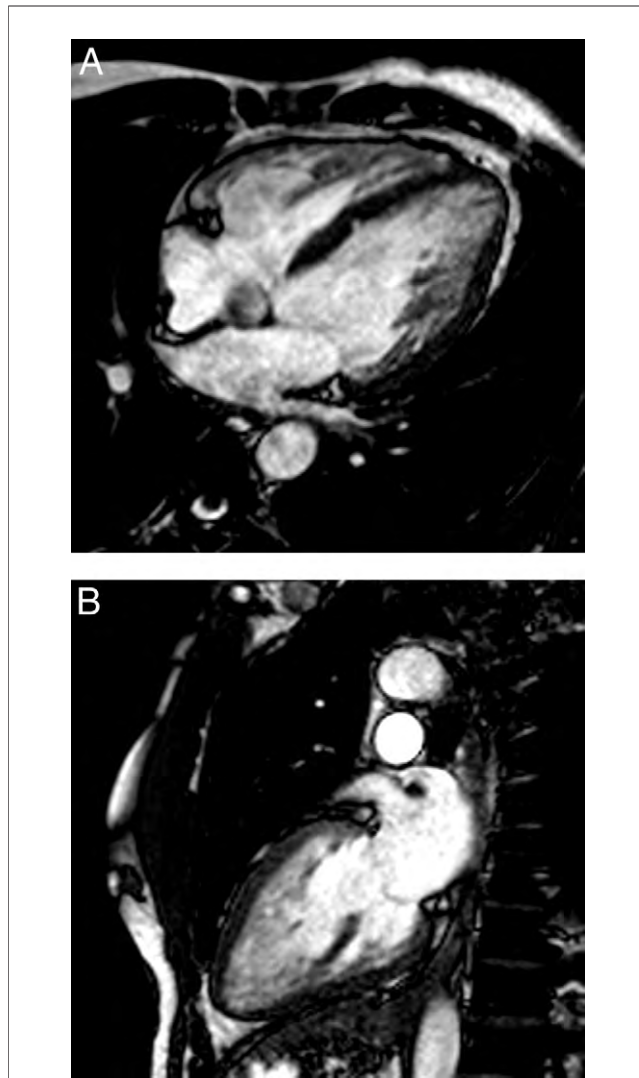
Cardiac Magnetic Resonance Imaging Demonstrating Morphological Noncompaction
